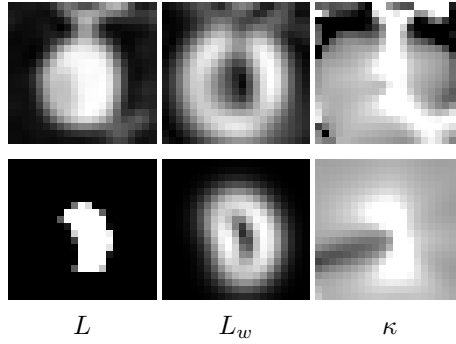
Intensity (L), gradient magnitude (L_w) and isophote curvature (κ) of a CT image without erf-clipping (top row) and of the same image with erf-clipping (bottom row). Note the shape of L_w and the negative (dark) values of κ in the erf-clipped images. Erf-clipping allows analysis of the shape of the lumen.
